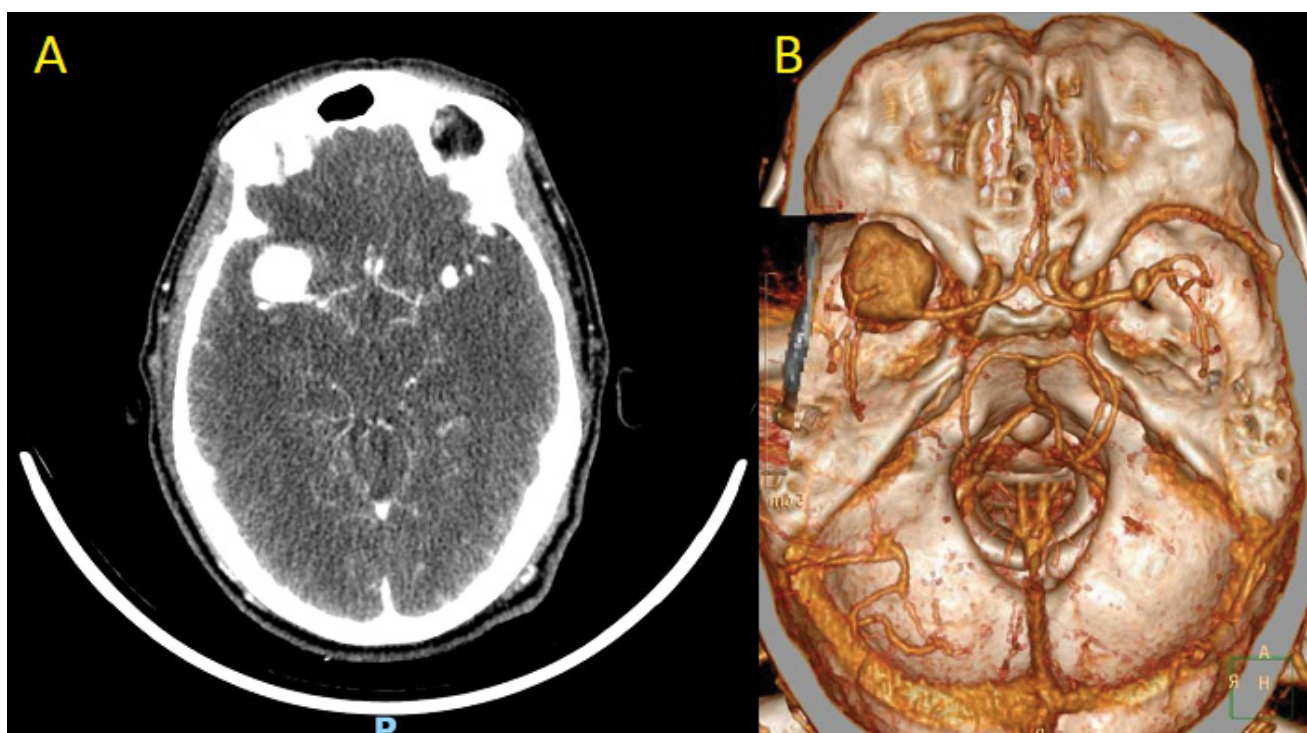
A) CT angiography of brain; B) CT angiography with 3D reconstruction of brain.
